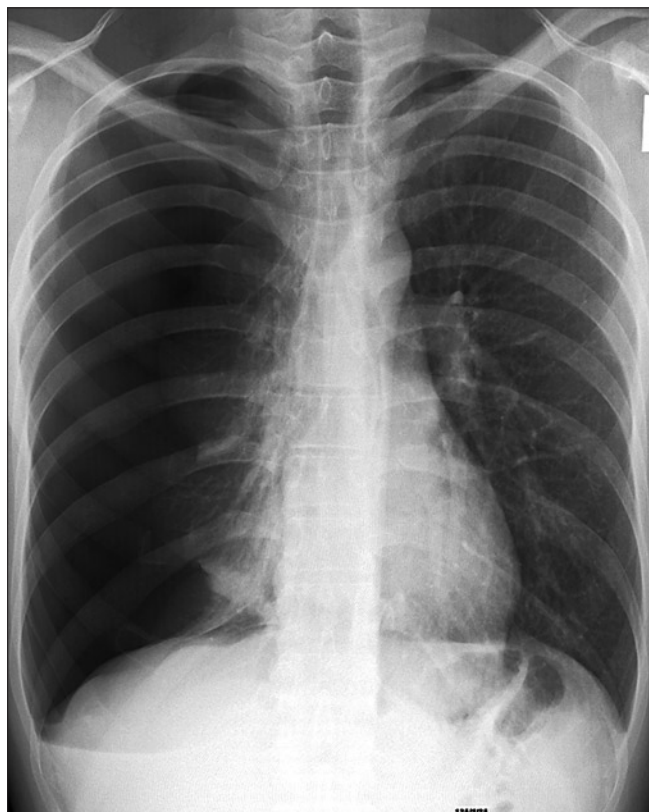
Tension pneumothorax – chest X-ray
